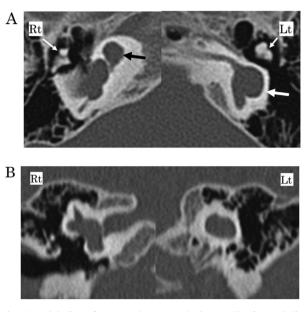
(A) Axial slice of computed tomography image. (B) Coronal slice of computed tomography image demonstrating IP-I (black arrow) and common cavity deformity (white arrow). The ossicles showed no malformations (thick white arrow).
